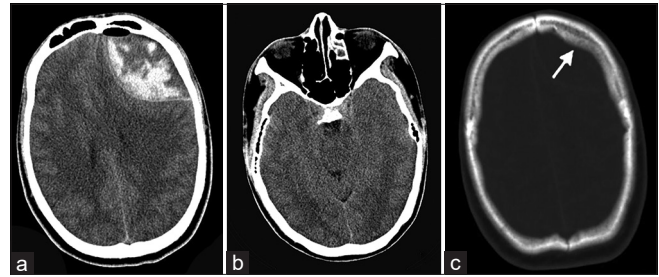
Head CT scan, preoperative CT scan of the head showed a mixed density lenticular mass with some air collection in the left frontal region (a), associated with effacement of the left ambient cistern (b). The bone window revealed thickening of the left frontal bone (c, arrow).
